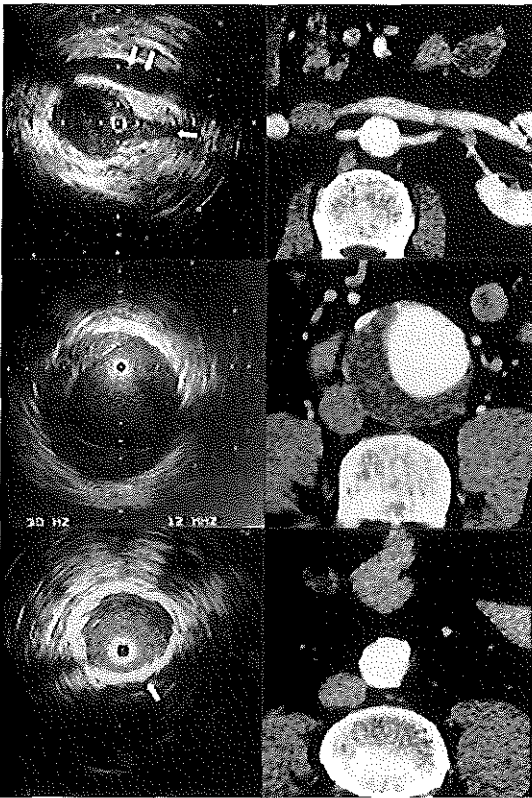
Comparison of computed tomographic angiography images and intravascular ultrasound images (12.5 MHz) obtained in the proximal neck, the aneurysm and the iliac arteries.
